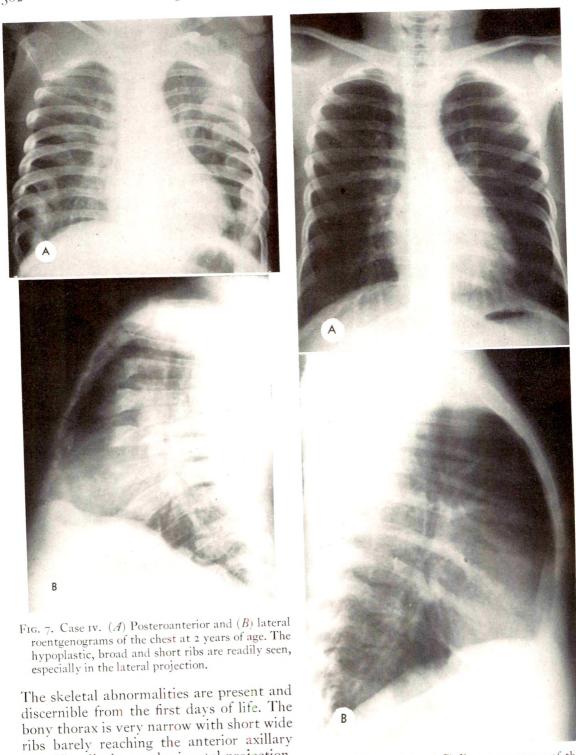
Case III. (A) Posteroanterior and (B) lateral roentgenograms of the chest, again showing the characteristic deformity with short and stubby ribs.
